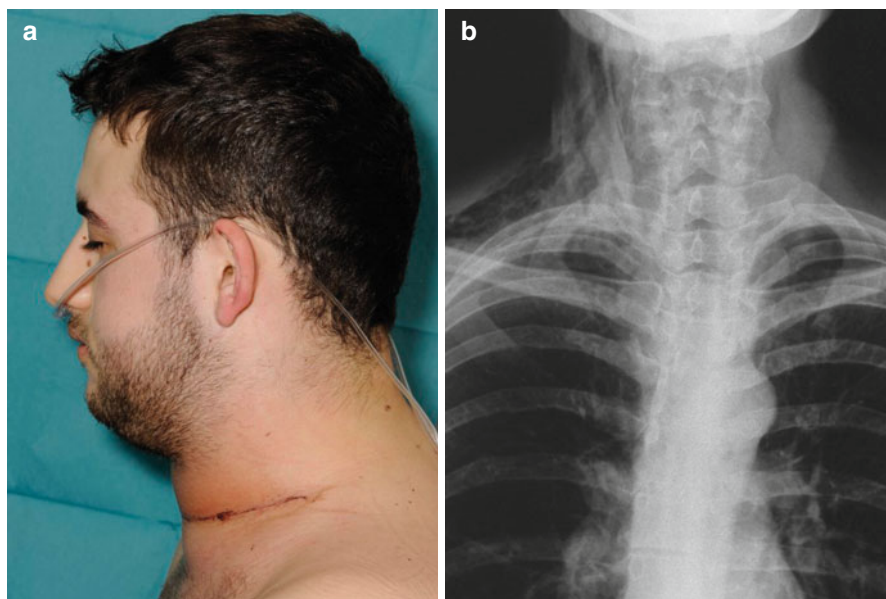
(a) Swollen neck in a man with tracheal injury following thyroidectomy. (b) Surgical emphysema on plain X-ray
